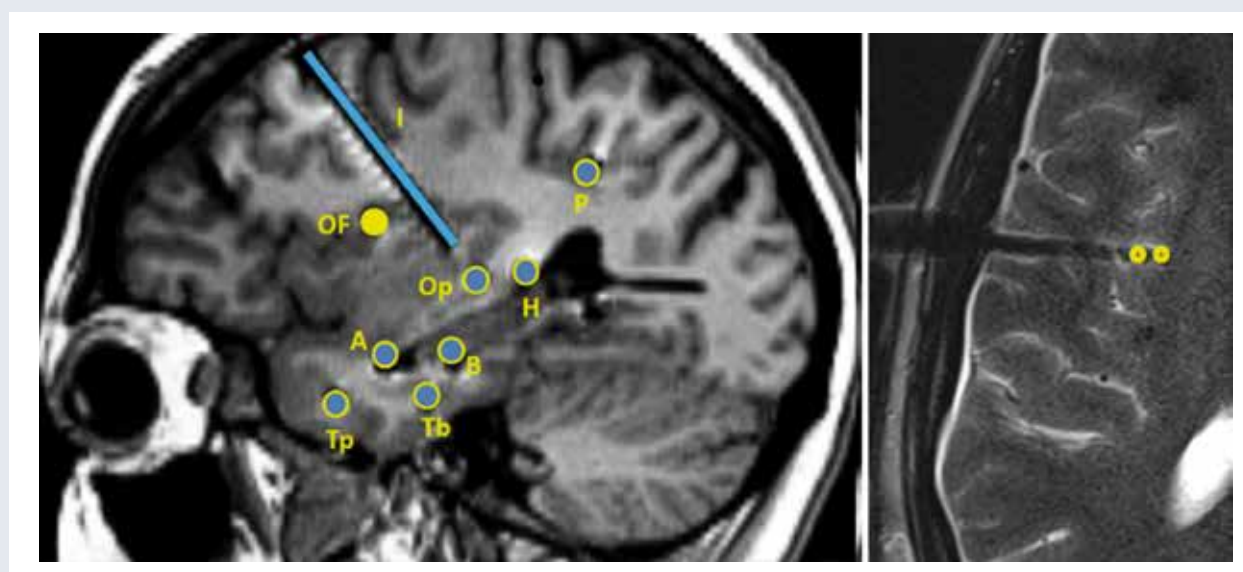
Sagittal view of the patient's MRI with localization of intracerebral electrodes. Nine electrodes were implanted with each of them containing 10-15 contacts. Electrodes A, B and Tb explore the right medial temporal lobe. Electrodes I (insula) and OF (frontal operculum) reach the right insular cortex. Right part: axial view, with detail of the electrode OF reaching the anterior-dorsal part of the insula. The two first contacts (1 and 2) are highlighted in yellow. Bliss sensation was elicited by bipolar stimulation (1-1.6 mA, 4 sec-train duration) of these contacts.
